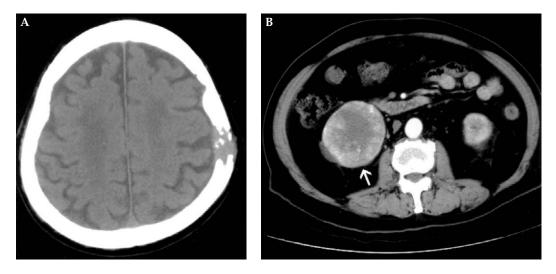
(*A*) Axial computed tomography (CT) scan of the head shows a mass lesion at the left parietal area of the skull with bone destruction. (B) Axial CT scan of the abdomen reveals a well-enhanced tumor (arrow) with central necrosis in the right kidney.
